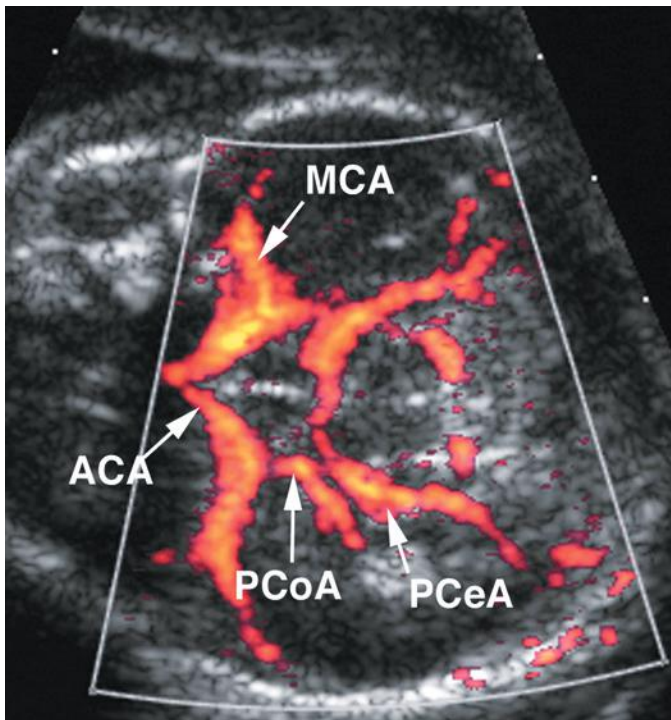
The circle of Willis is well seen on this nondirectional color Doppler image. ACA, anterior cerebral artery; MCA, middle cerebral artery; PCeA, posterior cerebral artery; PCoA, posterior communicating artery.
